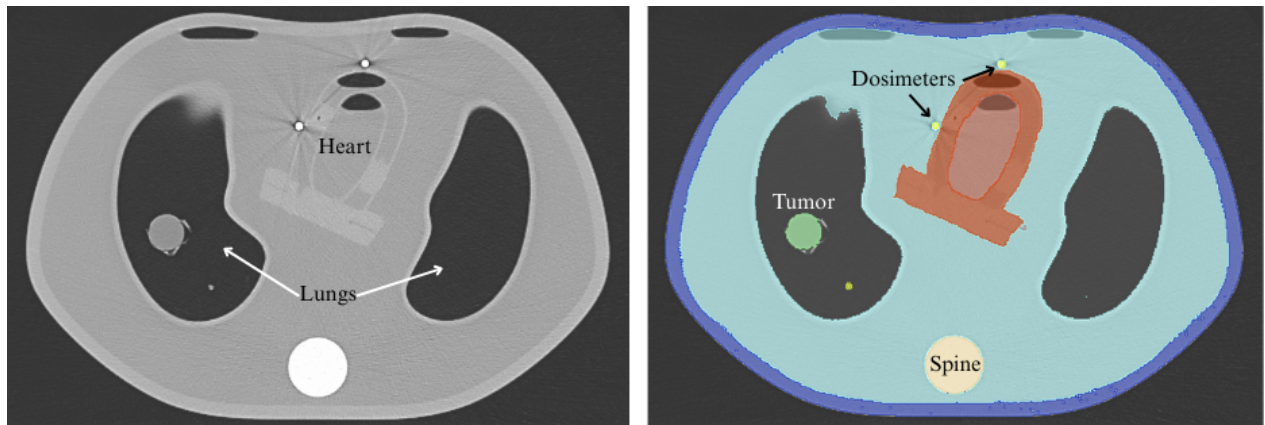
Segmentation of CT slice
